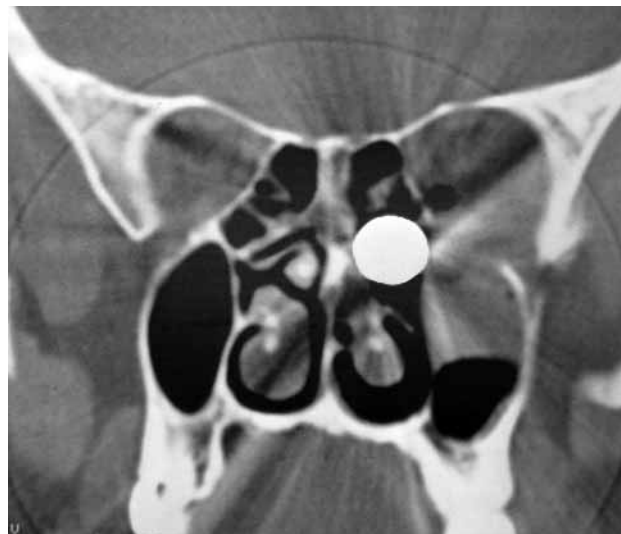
Coronal computed tomography scan showing the round foreign body in the left posterior ethmoidal sinuses.
